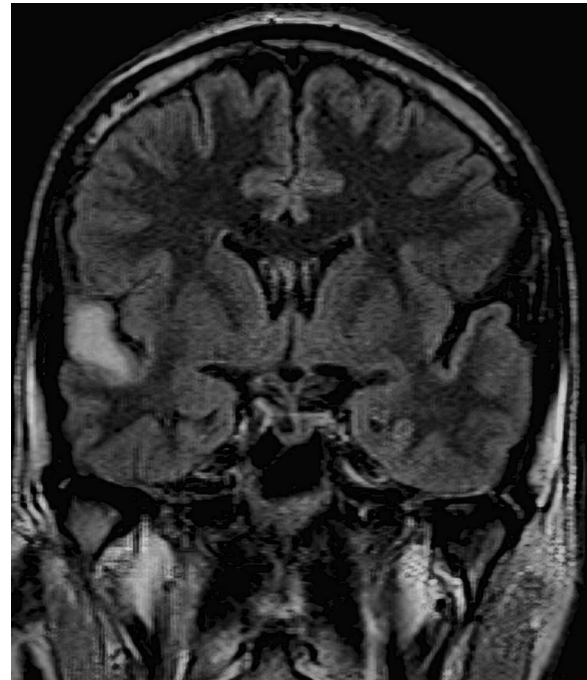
Magnetic resonance imaging (MRI) T2-weighted imaging of the brain revealing a small high-intensity lesion in the right temporal lobe
